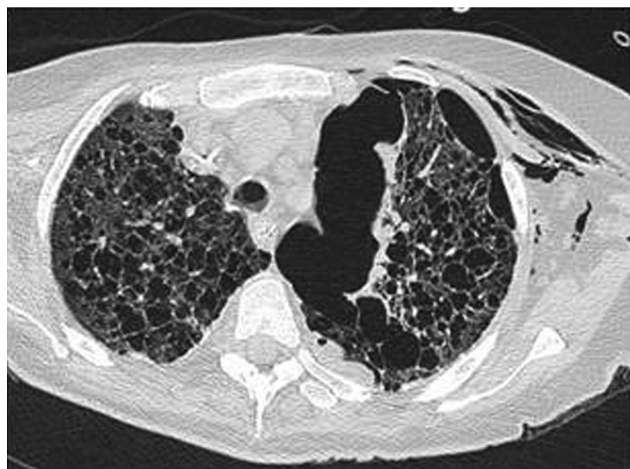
Computed tomography shows a left-sided pneumomediastinum.
